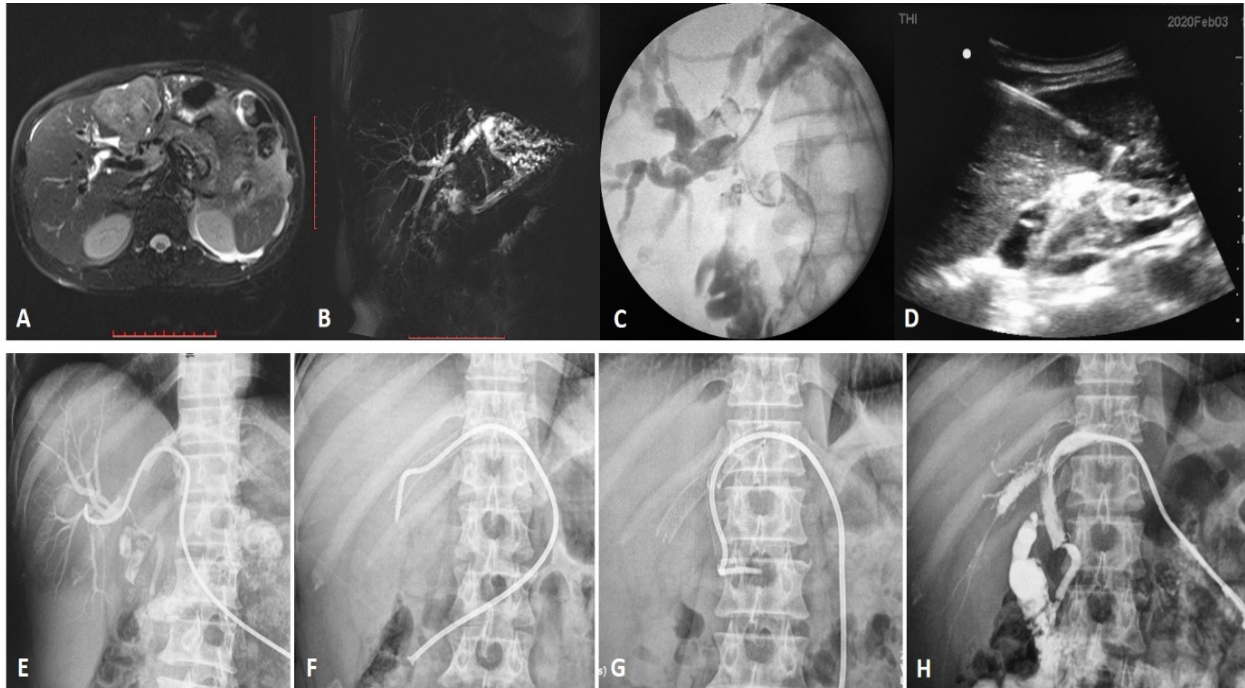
Bilateral T-stent for the management of type II hilar obstruction. (A, B) T2W FS MRI and MRCP showed a mass-forming and an intraductal tumor causing prominent left IHD dilatation. (C) A left-to-right PTBD was performed with multiple side holes. Cholangiogram demonstrated a filling defect at the confluence. (D) Intraoperative biopsy was performed which later confirmed the diagnosis of cholangiocarcinoma. (E, F) A left-to-right stent was deployed. Cholangiogram showed patency of stent. Note the filling defect within the stent (tumor ingrowth) and severe stricture of the common hepatic duct and proximal CBD. (G) A left-to-CBD stent was subsequently inserted through the struts of the initial stent. (H) Follow-up cholangiogram confirmed the stent patency without IHD dilatation. The drainage catheter was removed shortly.
